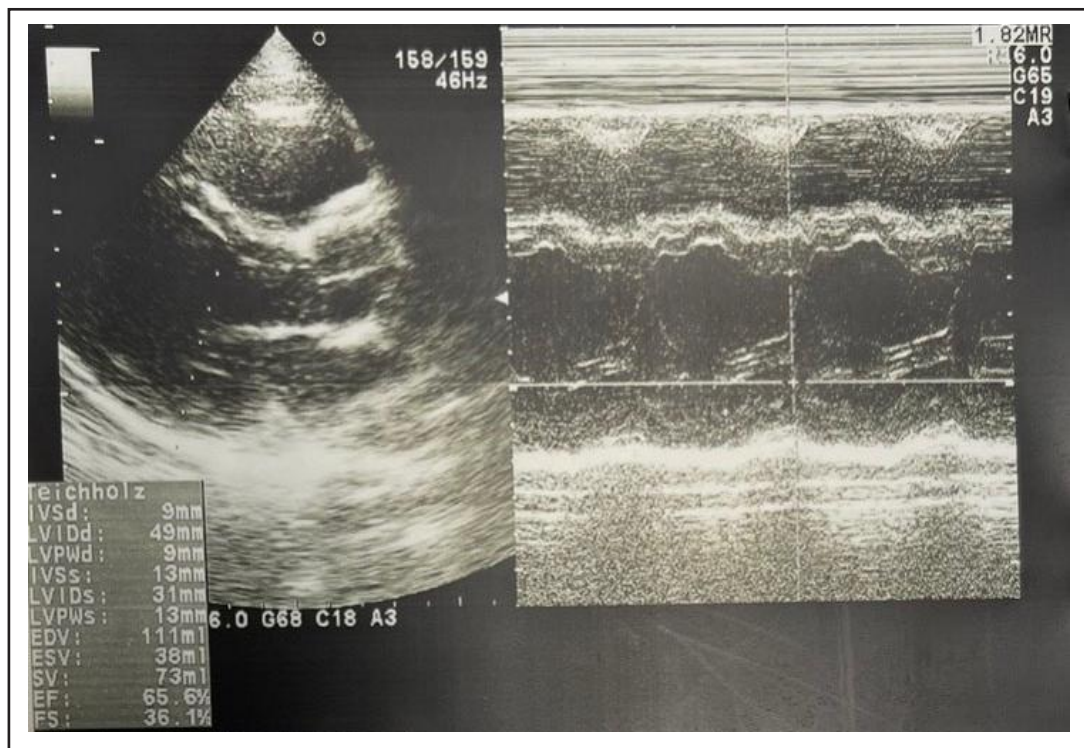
Result of Echocardiogram.
